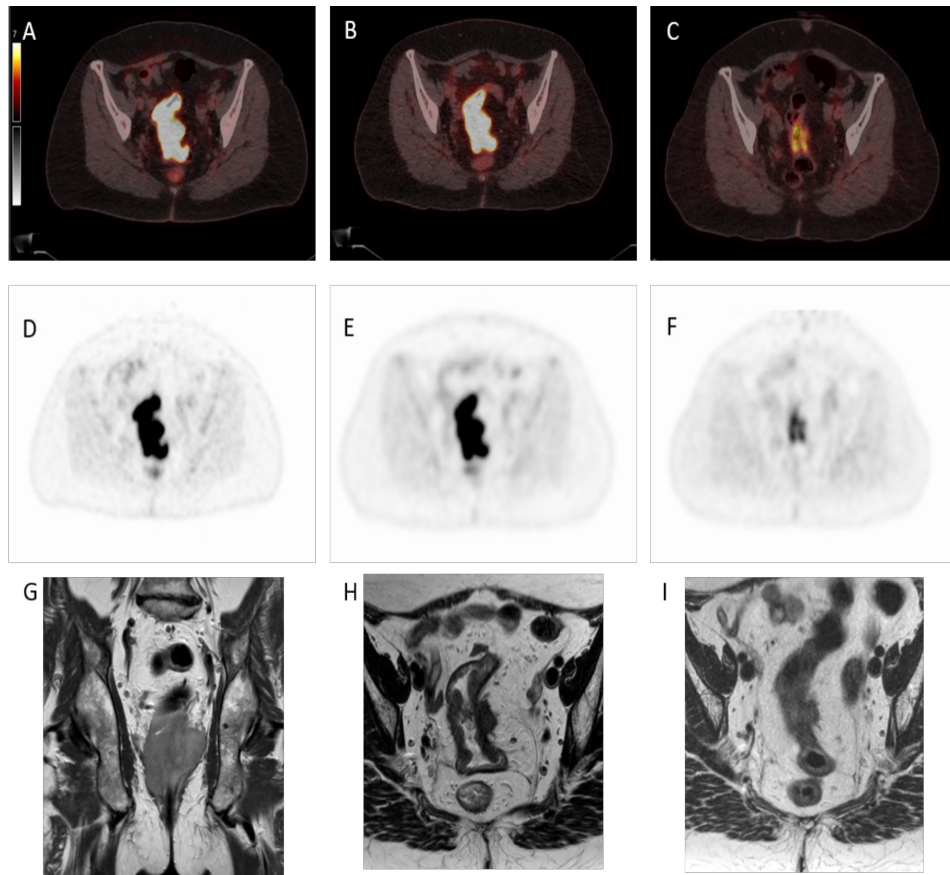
[¹⁸F]FDG PET/CT and T2 weighted MRI images of a poor responder before, during and after neoadjuvant chemoradiotherapy. Fifty-eight year old woman with cT4aN2M0 rectal cancer had a partial response to chemoradiotherapy to a yiT3N1M0. Pathological examination showed a ypT3N0M0 tumor and pTRG of 4. SUV_{max} was 17.8 at baseline, 17.8 at interim assessment, and 6.5 at re-evaluation. Figure shows [¹⁸F]FDG PET/CT fusion (A, B, C) and PET-only (D, E, F) images as well as T2 weighted MRI (G, H, I) images before (A, D, G), during (B, E, H) and after (C, F, I) neoadjuvant chemoradiotherapy.
